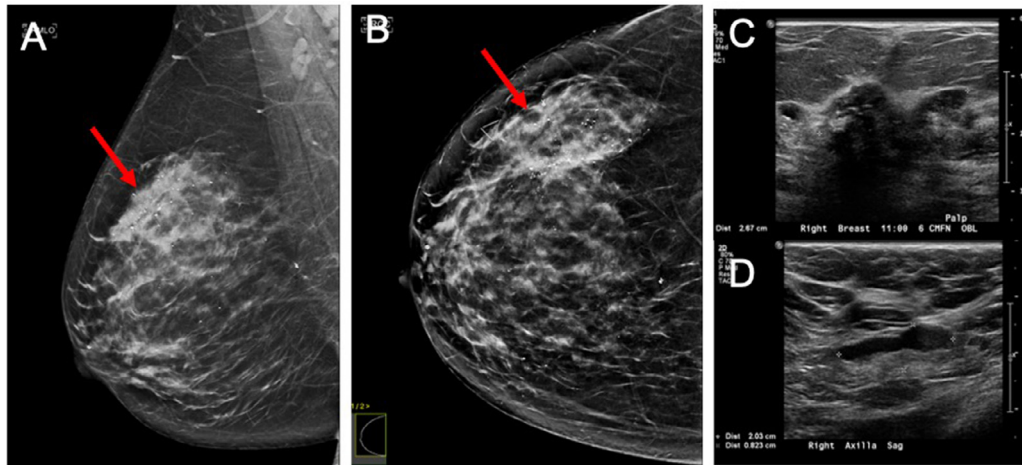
Breast Imaging. (A) Right mediolateral oblique and (B) craniocaudal mammograms with the arrows indicating the area of architectural distortion which was new compared to prior exams. There are also associated coarse heterogeneous calcifications. (C) Demonstrates an ultrasound image of the suspicious mass correlating with the mammographic architectural distortion and also correlating with the ^{68}Ga -DOTATATE-PET avidity. (D) Shows the enlarged right axillary lymph node correlating to the ^{68}Ga -DOTATATE PET finding.
